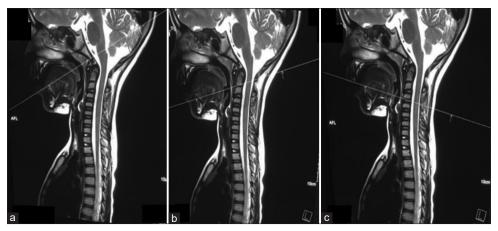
Magnetic resonance imaging in sagittal view: showing image acquisition at the level of (a) soft palate, (b) base of the tongue and (c) epiglottis
